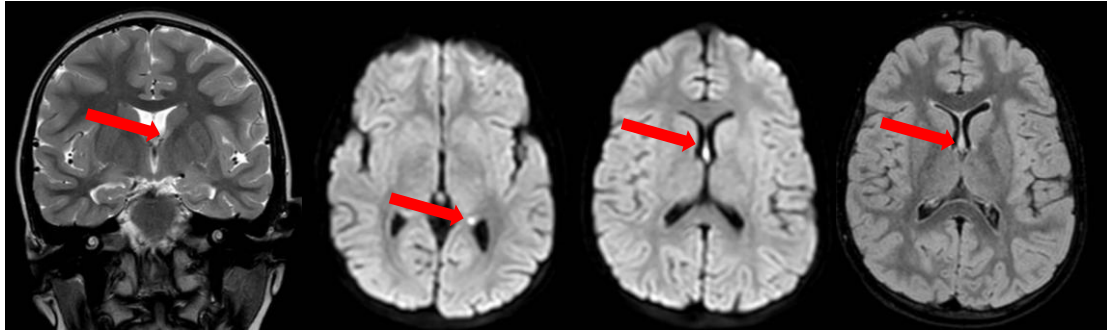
5.11 years. Left amygdalo-hippocampal swelling, mildly hyperintense on T2-weighted and FLAIR sequences, with diffusion restriction on DWI extending to the ipsilateral fornix and hippocampal tail, consistent with excitotoxic changes (red arrows).
